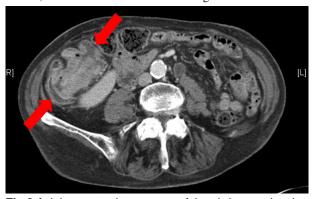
Axial computed tomogram of the abdomen showing an apple core stricture at the hepatic flexure (between red arrows)
